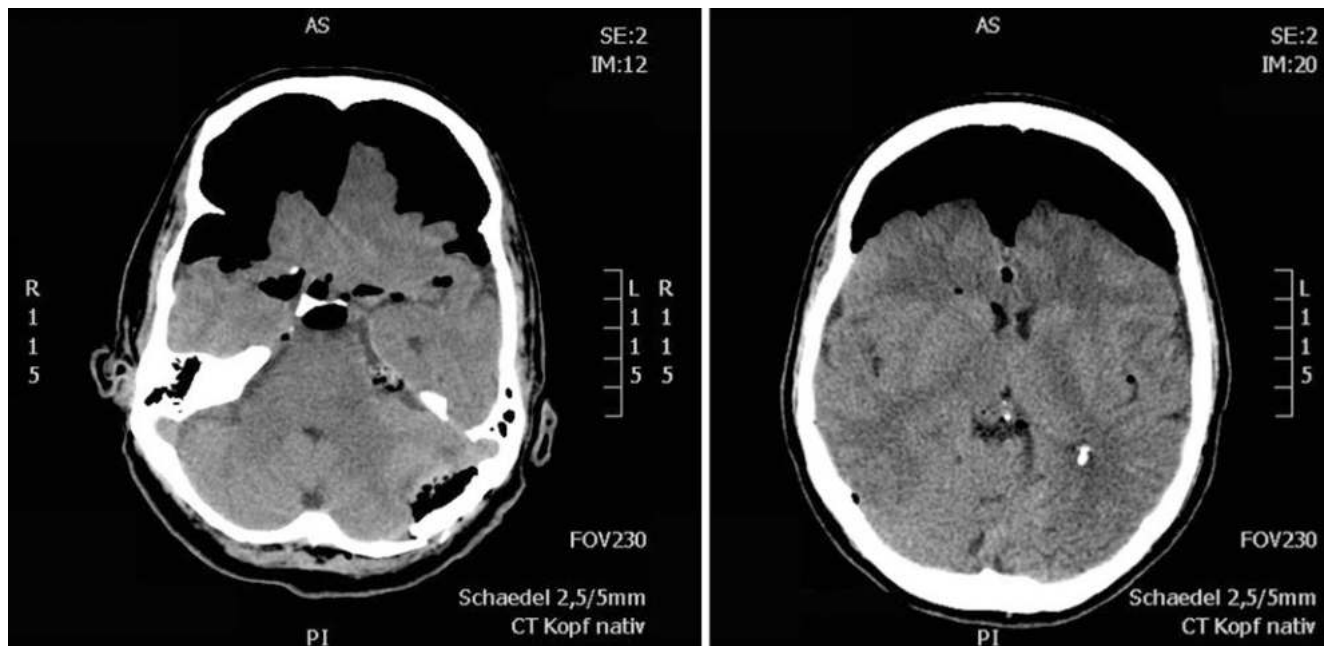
Postoperative CT scan demonstrating a large pneumocephalus following acoustic neurinoma resection
